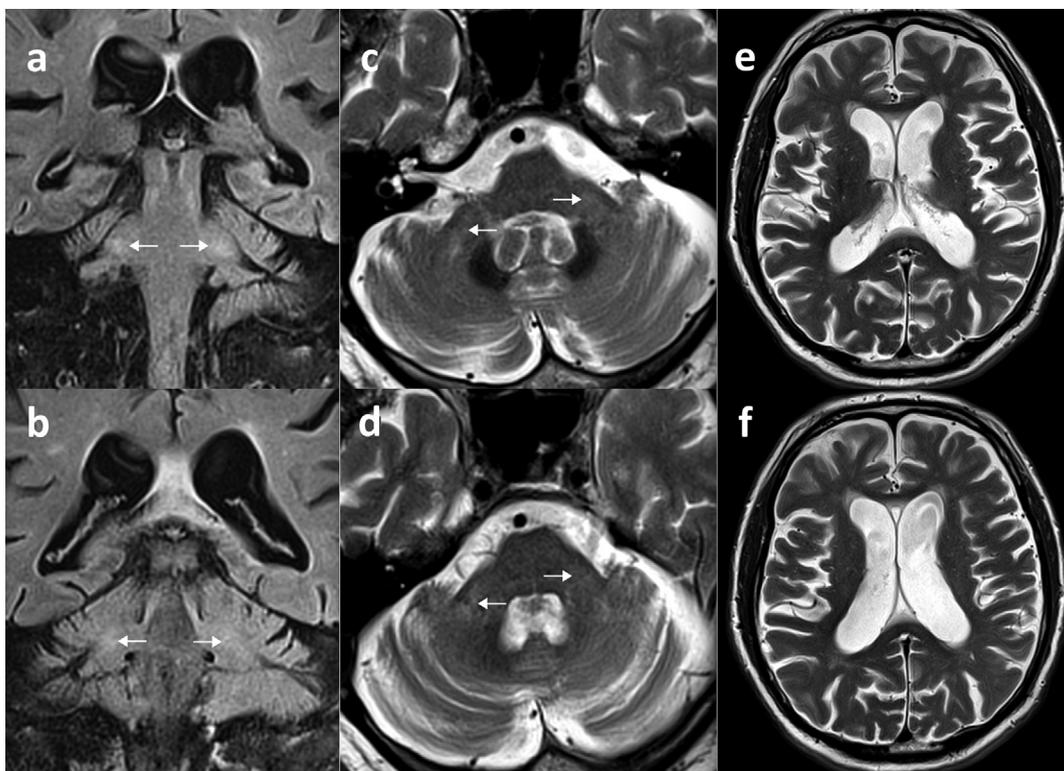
Images of the initial MRI performed on a 3.0 T Siemens MR scanner. Coronal FLAIR (a and b) images show mild hyperintensity in the middle cerebellar peduncles (arrows). Minimal hyperintensity on axial turbo spin echo T2 weighted images (c and d, arrows) is hard to distinguish from artifacts. Moderate cortical-subcortical cerebral atrophy and mild hyperintensity of the periventricular white matter are seen on the axial T2 weighted images e and f.
